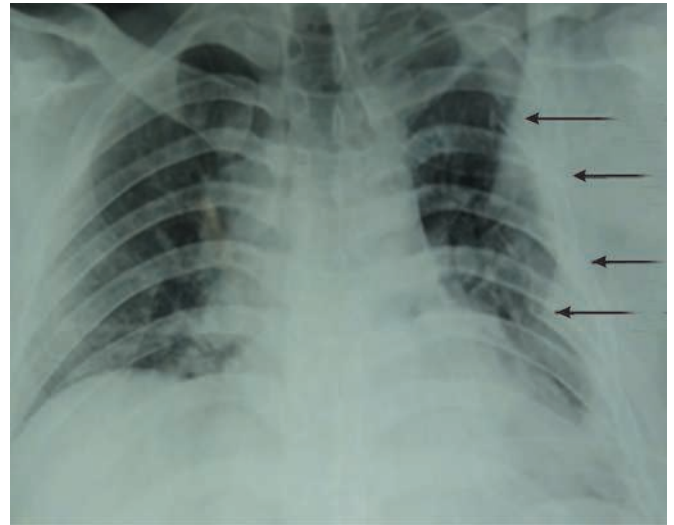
Chest radiograph showing 2nd-5th rib fractures on left side
